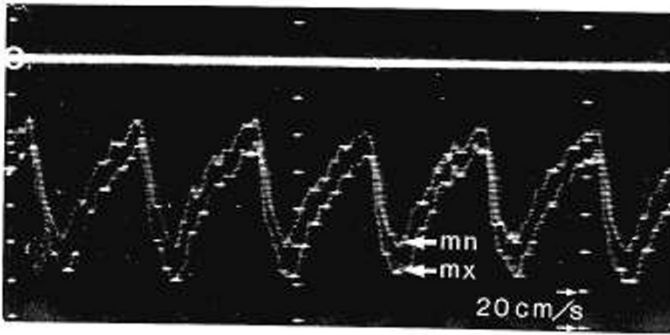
The Doppler velocity recordings from the umbilical artery, with the electronic instantaneous maximum (*mx*) and mean (*mn*) velocities demonstrated. The white horizontal lines represent zero (0) velocity. Each calibration division represents 20 cm/s (white arrows).
